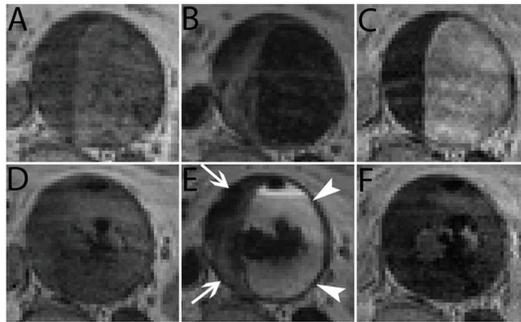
Precontrast T1-weighted (A,D), T2-weighted (B,E) and postcontrast T1-weighted (C,F) images through the aneurysm sac of one patient on the same anatomical location. The upper row is acquired before EVAR, the lower row one day after EVAR. On the postoperative T2-weighted image (E) the pre-existent thrombus (arrows) has a lower signal intensity than the blood excluded from the circulation (arrowheads). Ventral in the aneurysm sac a small amount of air is present which is a normal postoperative finding shortly after EVAR.
